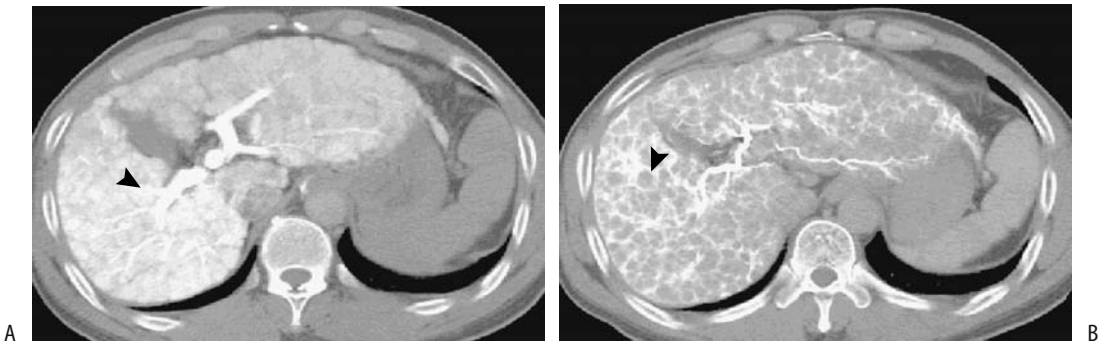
Regenerating nodules in a man with cirrhosis. A: CT arterial portography shows enhancing nodules (arrowhead) in an otherwise heterogeneous liver. B: CT hepatic arteriography reveals these nodules to be poorly enhancing (arrowhead). (Source: Kim HC, Kim TK, Sung KB, et al. CT during hepatic arteriography and portography. *RadioGraphics* 2002;22:1041–1051, with permission from the Radiological Society of North America.)
